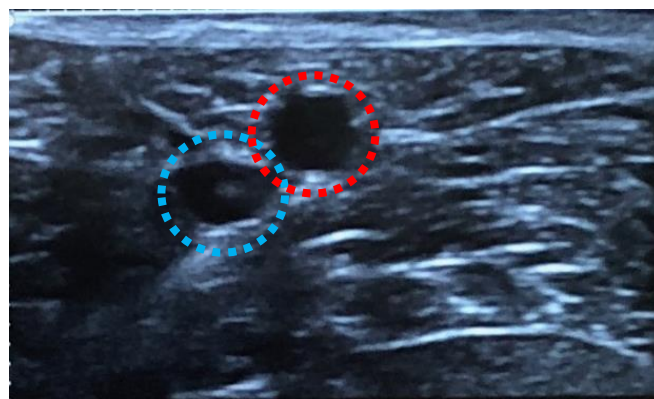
Ultrasound image of femoral artery and vein. Image demonstrates the femoral artery (red) and femoral vein (blue).
